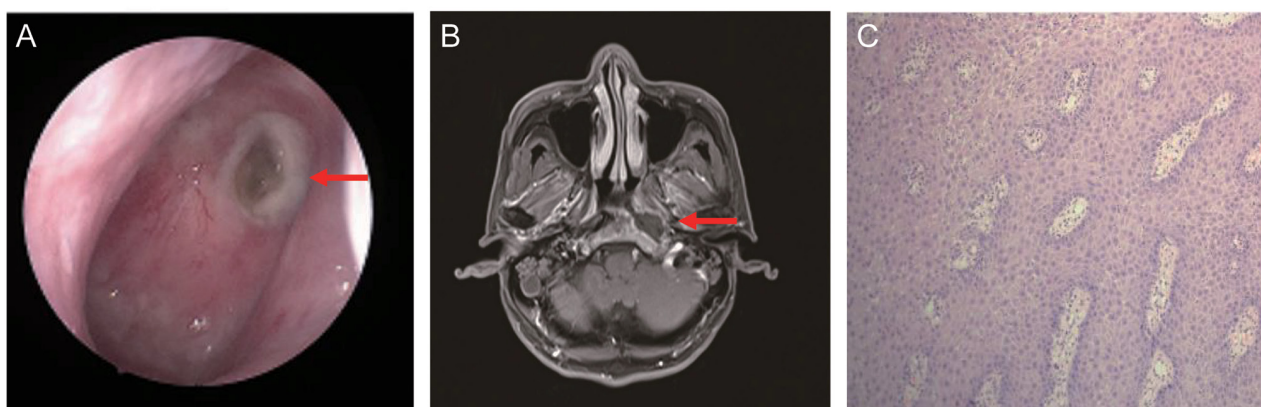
Images before treatment of case 1. (A) A nasopharyngoscope showed necrosis on the left side of the nasopharynx, with yellow dead tissue in the center of the lesion and purulent secretions (red arrow). (B) Transverse, contrast-enhanced, T1-weighted MRI revealed necrotic lesions (red arrow). (C) No tumor cells were identified in the lesion (magnification, x100).
